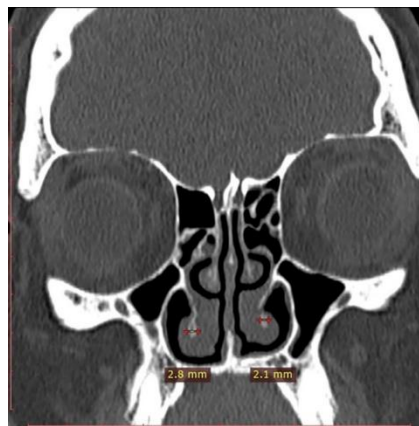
Coronal CT section – bony component of the inferior turbinate
